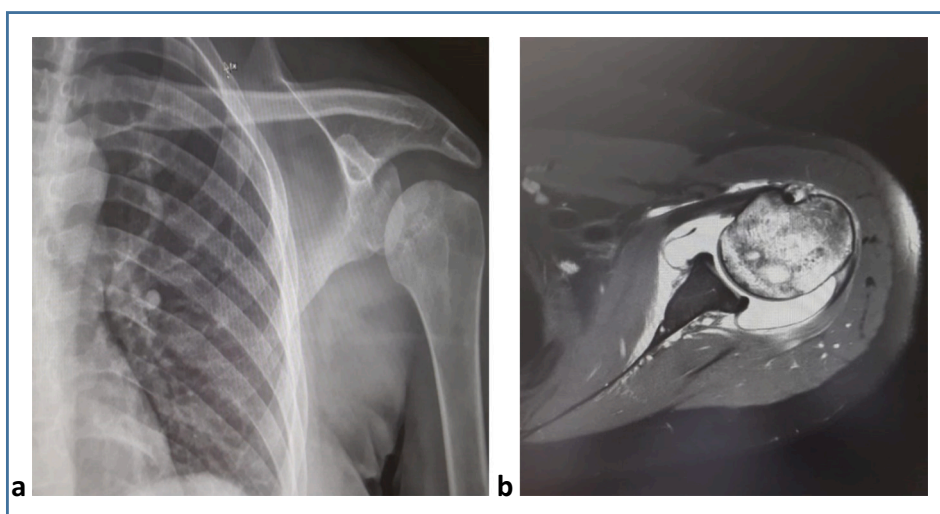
(a) AP radiograph of the left shoulder with mild inferior displacement of the humeral head, suggestive of joint effusion. (b) A T2 weighted axial cut showing cystic lesions in the humeral metaphysis, an intact cortex, and a large glenohumeral joint effusion.
